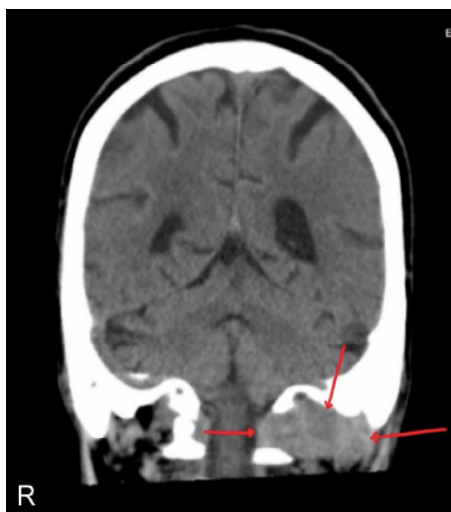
Coronal computed tomography angiogram of the head and neck demonstrating a 3.0 x 3.7 x 3.1 cm soft tissue density (arrows) located inferior and medial to the left mastoid process of the temporal bone and extending to the occipital condyle. There is an additional central hypodense region, which is a collection consistent with fluid or pus, concerning for Bezold abscess.
